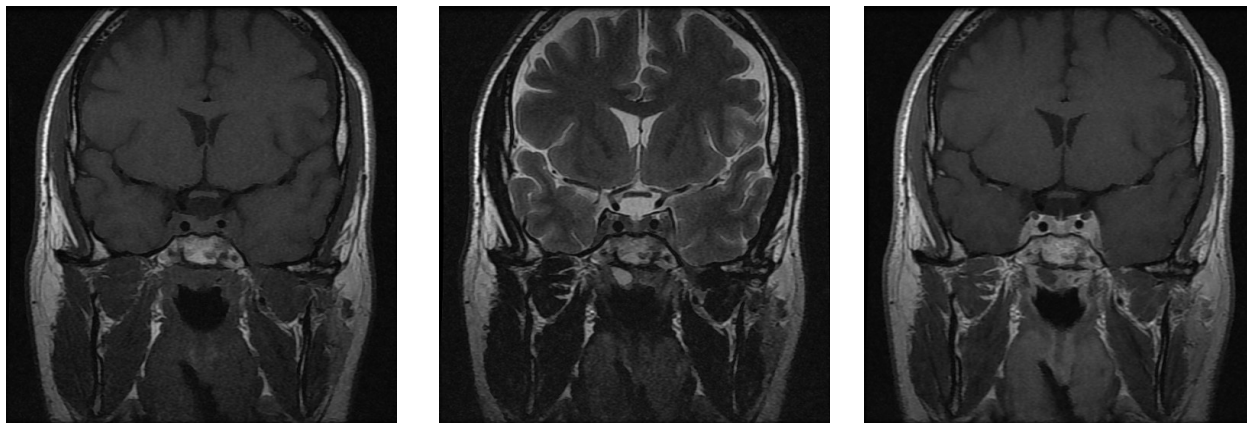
There is expansion of both cavernous sinuses which is more prominent on the left side. The signal change is isointense to muscle on T1 (Figure 2A) and T2-weighted (Figure 2B) images. There is prominent heterogenous enhancement after intravenous contrast administration (Figure 2C). The cavernous segment of the left internal carotid artery is narrowed. Please note some mild expansion and signal change in the right cavernous sinus compared to the other side.
